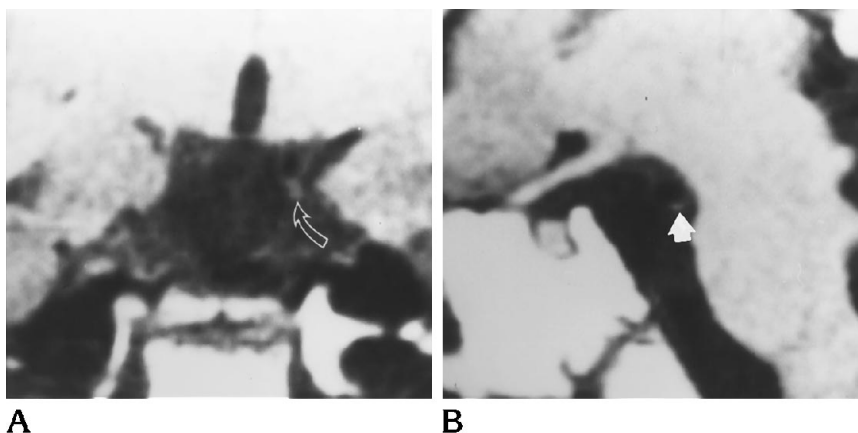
A, Traumatic avulsion of the third nerve is demonstrated on this parasagittal T1-weighted image, which does not fully show the third cranial nerve. Only a small residual stump (*arrow*) is noted between the superior cerebellar and posterior cerebral artery.
